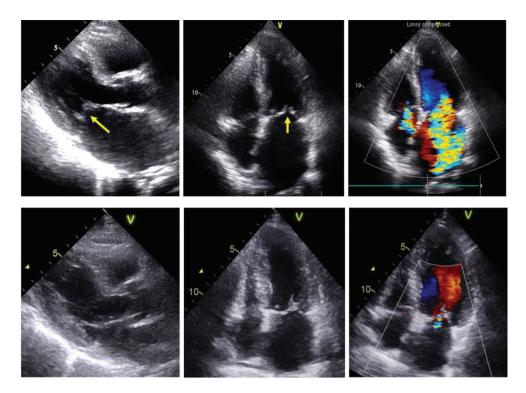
Transthoracic echocardiograms show dynamic change of mitral regurgitation. Mitral leaflets do not coaptation on end-systole (arrows at parasternal long axis view and apical four chamber view images on upper panel) and color Doppler image shows severe mitral regurgitation (right, upper panel). On follow-up echocardiograms immediately performed after right coronary artery intervention (lower panel), mitral valvular coaptation and severe mitral regurgitation are completely improved.
